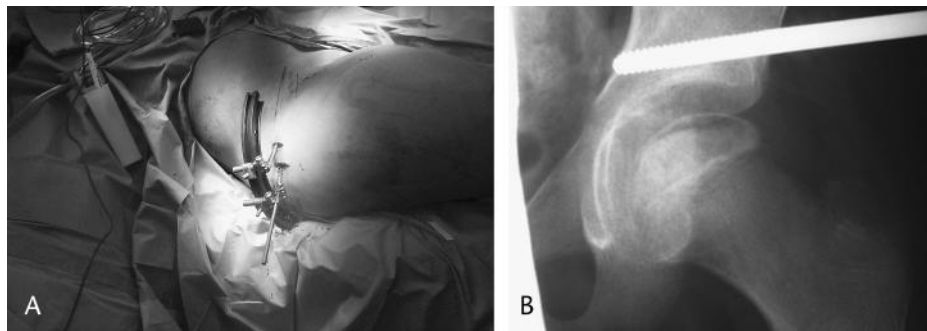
A, Intraoperative picture demonstrating positioning of 2 supra acetabular Schanz pins. B, AP left hip magnified x-ray demonstrating positioning of a supra acetabular Schanz pin.
